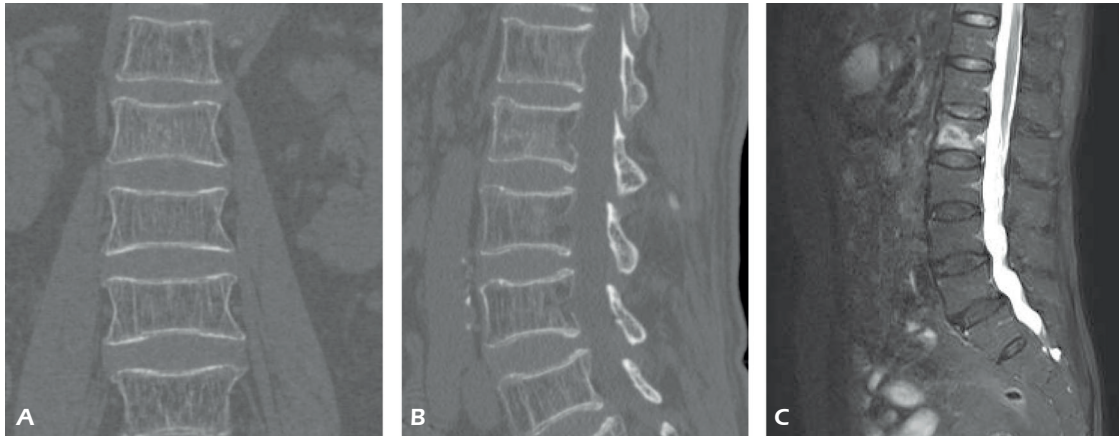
Radiological images of a case (83 years old) with L2 osteoporotic fracture. A, Coronal CT image. B, Sagittal CT image. C, MR image (increased signal intensity).
